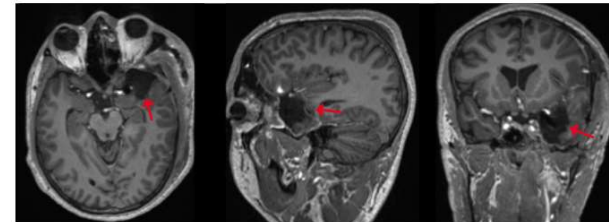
T1-weighted MRI images showing the complete resection of AVM nidus (red arrows).
